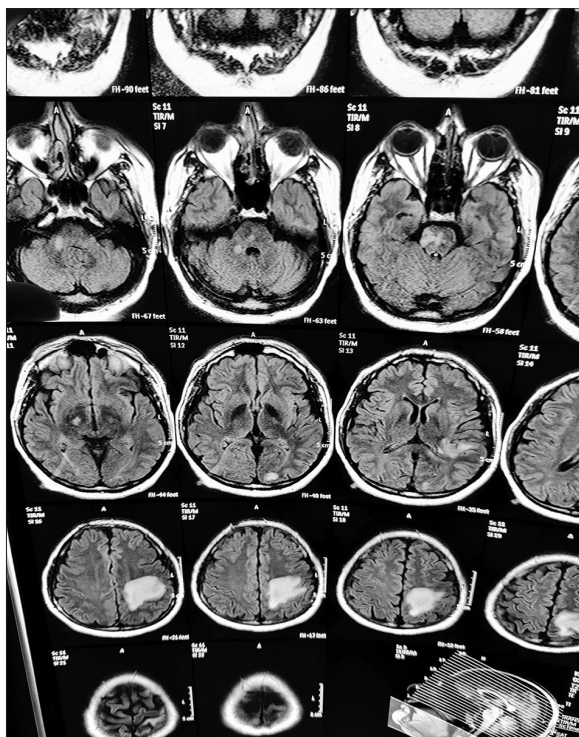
FLAIR axial image reveals hyperintense lesion in the temporal lobe extending into the occipital region with mass effect on the adjacent lateral ventricle
